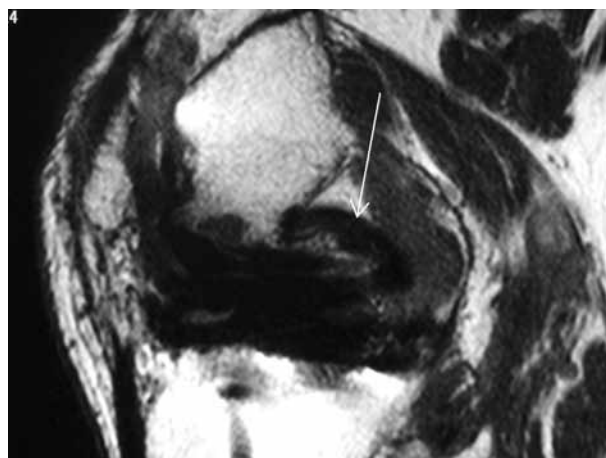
Sagittal T2 MRI image delineating an intact PCL (white arrow) (case 11 left knee).
